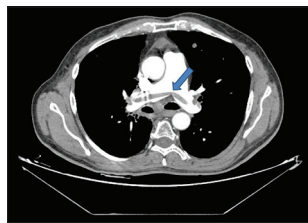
Computed tomography thorax done on the day of admission when patient developed breathlessness after 13 days of starting immunotherapy and scan showing a saddle thrombus in pulmonary artery
